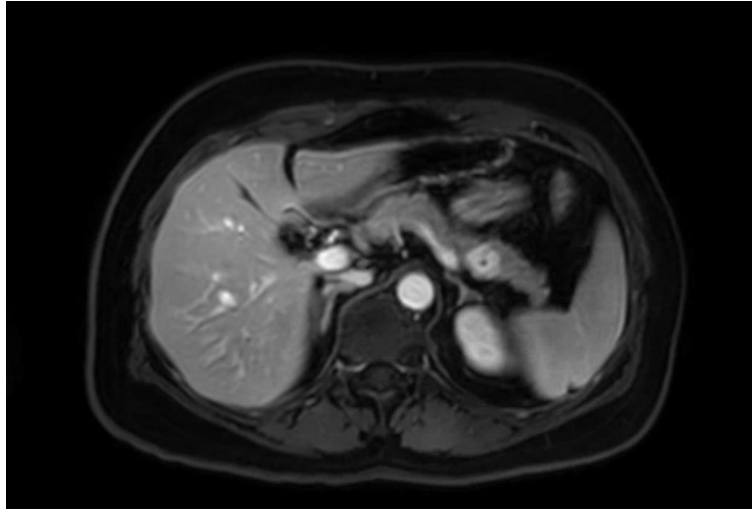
MRI-scan showing a hypervascular lesion in the tail of the pancreas found to be an insulinoma.
